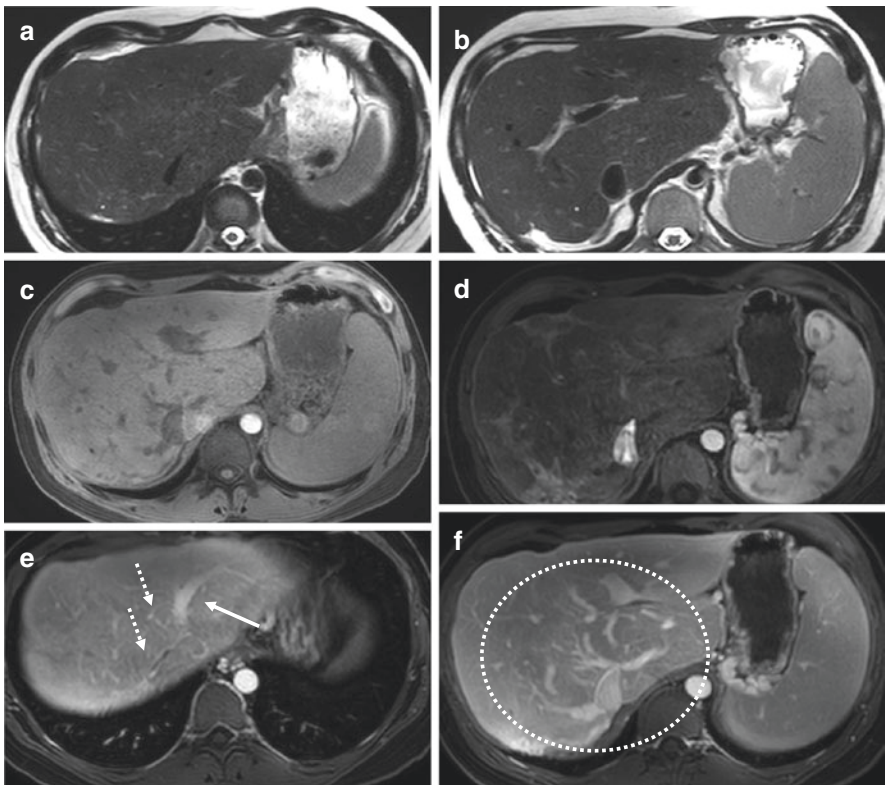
Typical MRI aspect of chronic Budd–Chiari syndrome in a 45-year-old male with myeloproliferative neoplasm. T2-weighted (a–b) and pre-contrast fat-saturated T1-weighted (c) images shows a dysmorphic liver with right liver atrophy and hypertrophy of the caudate lobe associated with irregular contours. After injection of extra-cellular contrast agent, the liver shows heterogeneous enhancement on arterial phase images (d). On portal venous phase (e–f), the left hepatic vein remains patent (arrow), while the right and middle hepatic veins are chronically occluded (dashed arrows). Multiple intrahepatic venous collaterals are visible (circle in f)
